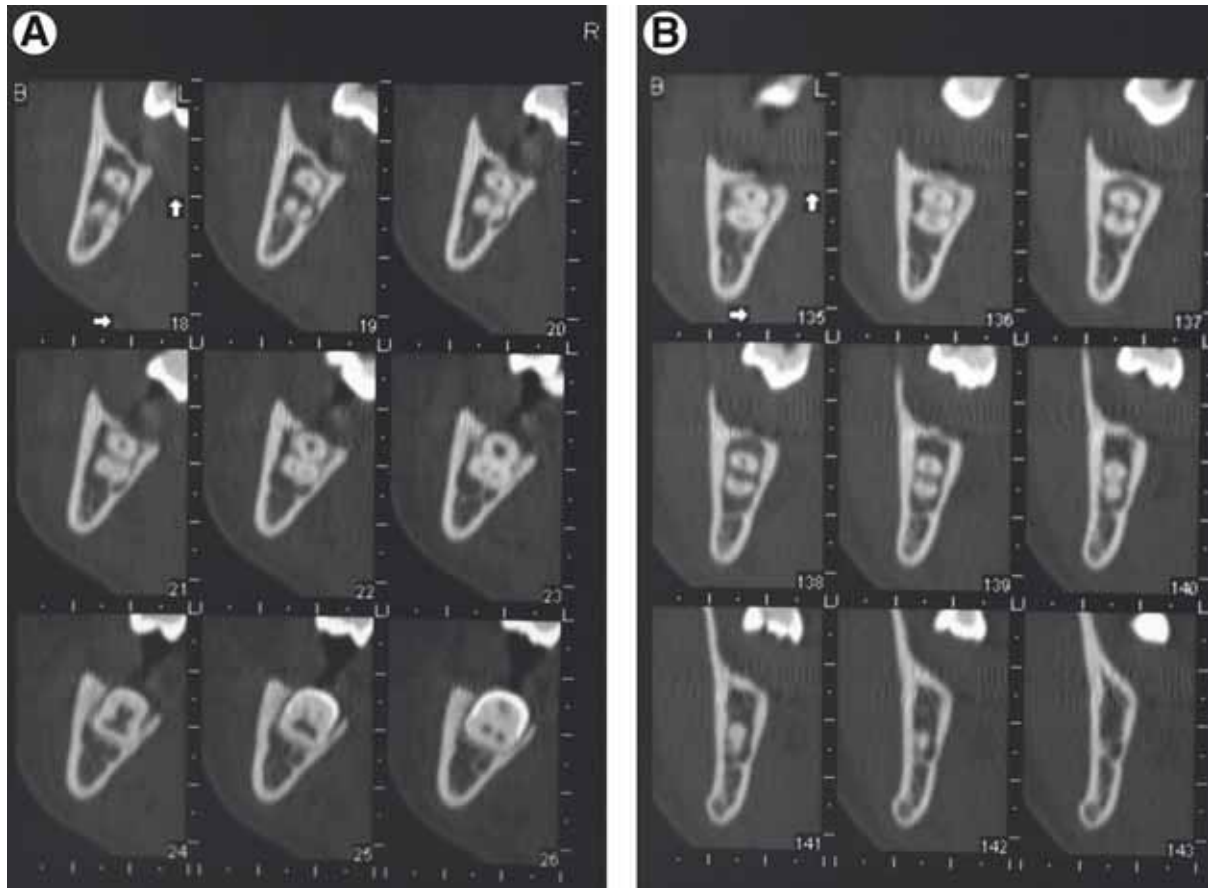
A, B, Computed tomography scan of third molar area. The tight relationship of the roots with the nerve bundle is clearly visible. Extraction would result in a high risk of nerve injury.
